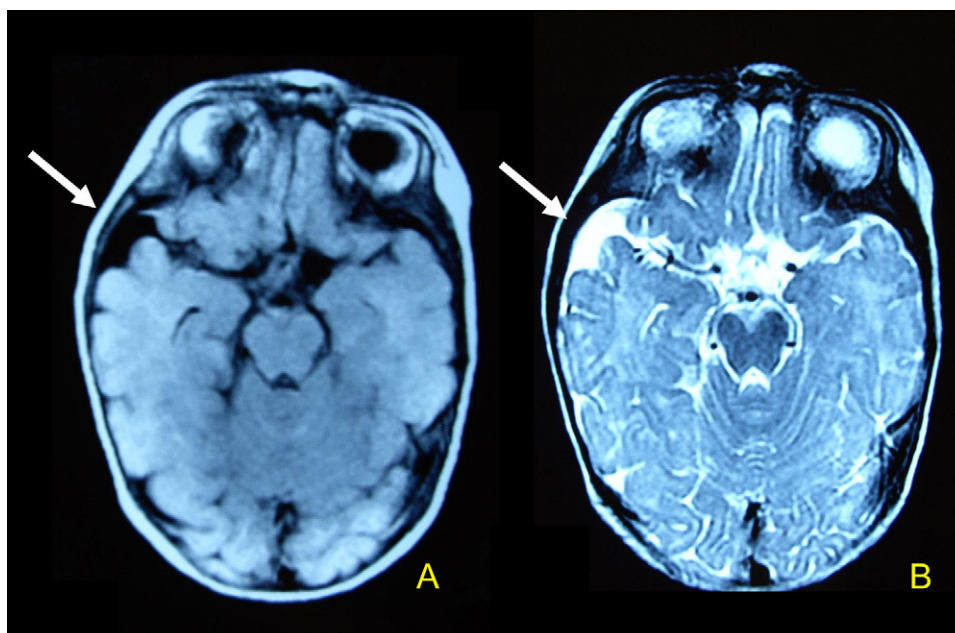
Arachnoid cyst occupying the right temporal fossa. A, brain axial T_1 -weighted magnetic resonance imaging; B, brain axial T_2 -weighted magnetic resonance imaging.
